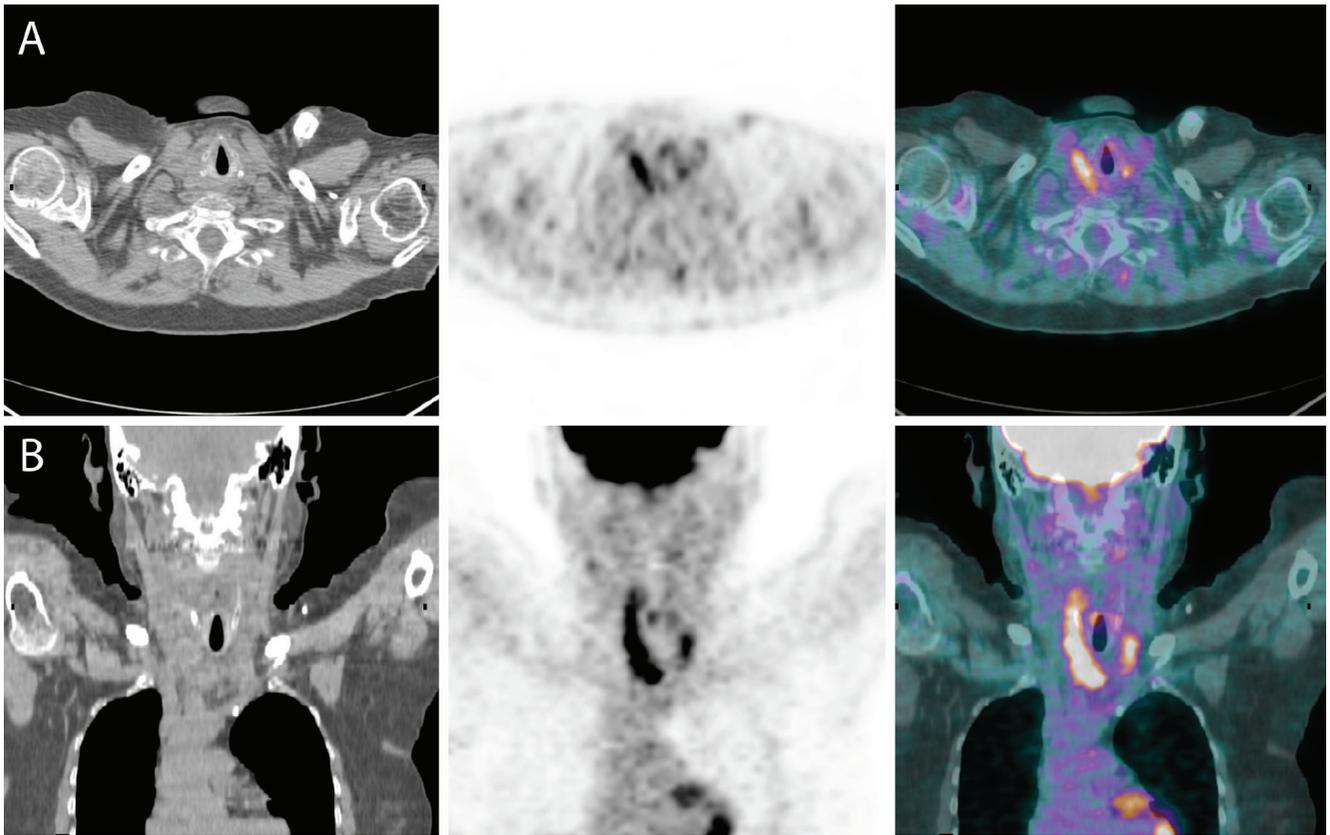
(A) Transaxial and (B) coronal views of the post therapy PET/CT showing apparent partial response to therapy.
